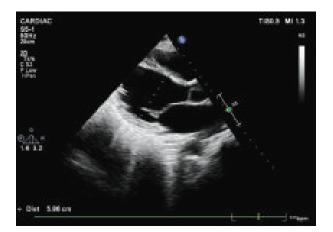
Echocardiography revealed dilated left ventricle
